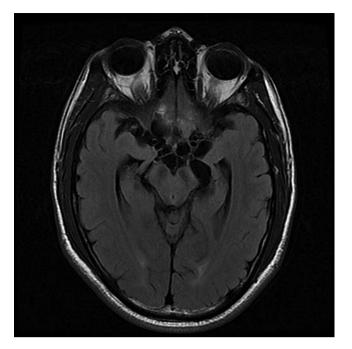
T2 axial flair MRI demonstrating suprasellar and prepontine cistern multiple septated cystic lesions with slight enhancement consistent with racemose neurocysticercosis.
